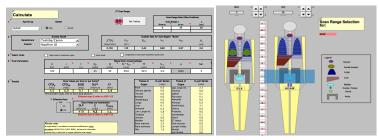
CT Expo Interface "Calculate" and "Scan ranger" [7].
